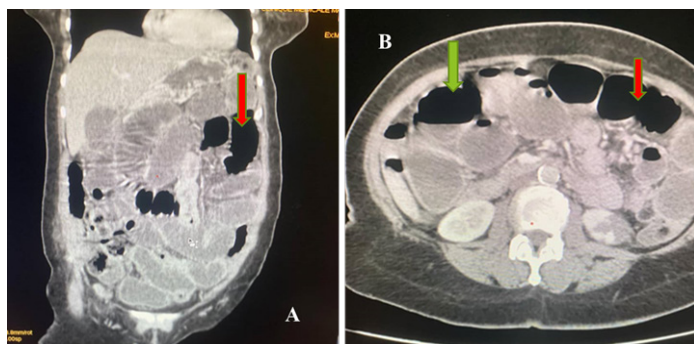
(A and B) : Abdominal CT scan in coronal (A) and axial (B) reconstruction revealed small intestinal distension measuring 34 mm in antero-posterior diameter (Red arrow), located at the hydro-aeric level (Green arrow).
